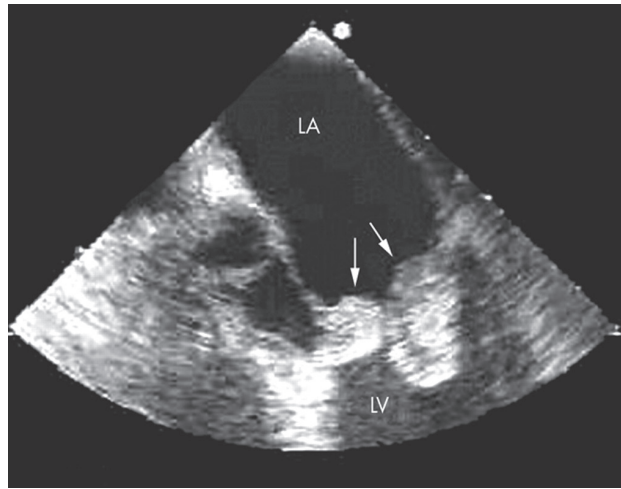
Transesophageal echocardiogram of infected mitral bioprosthesis.
